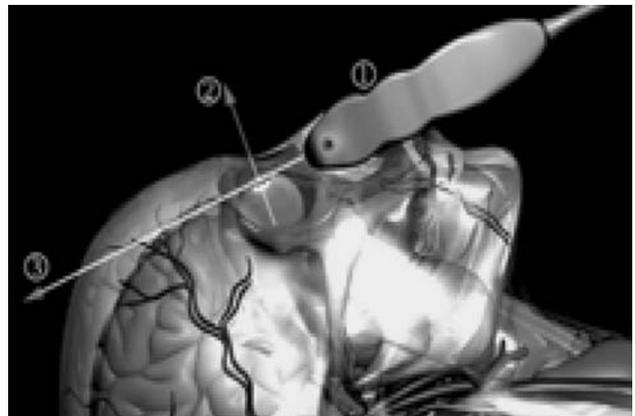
The ultrasound scanning plane transects the globe in its coronal plane through the iris: 1 the ultrasound probe; 2 the direction of gaze; 3 the scanning plane (Courtesy of Butler Graphics, Inc.)
